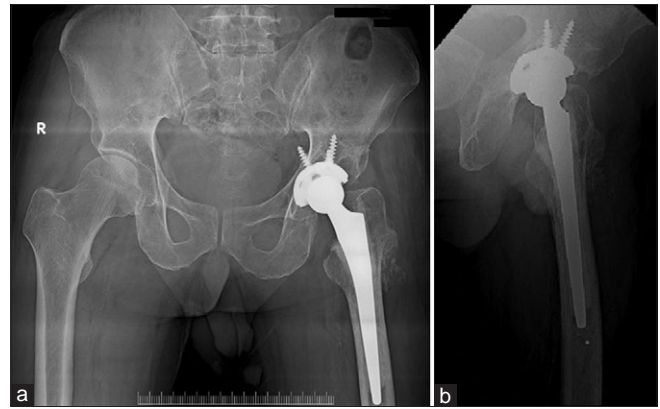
X-ray of the pelvis with both hips-Anteroposterior view (a) and X-ray left hip-lateral view (b) at 1 year follow-up after left total hip arthroplasty of the patient showing good alignment, positioning, and fixation of the components
